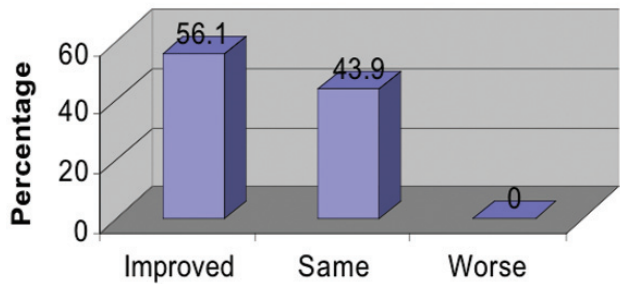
Effect on infarcted segments injected with stem cells: echocardiography analysis.
